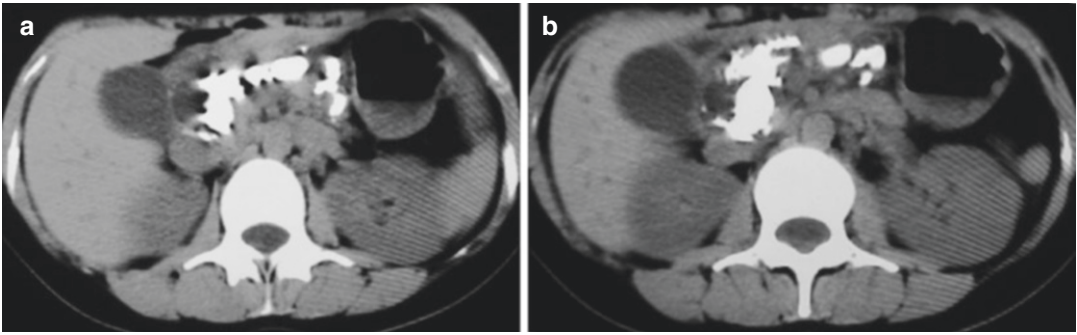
CT before the surgery revealed a large number of patchy high-density shadows in the pancreas, and gallbladder distended
